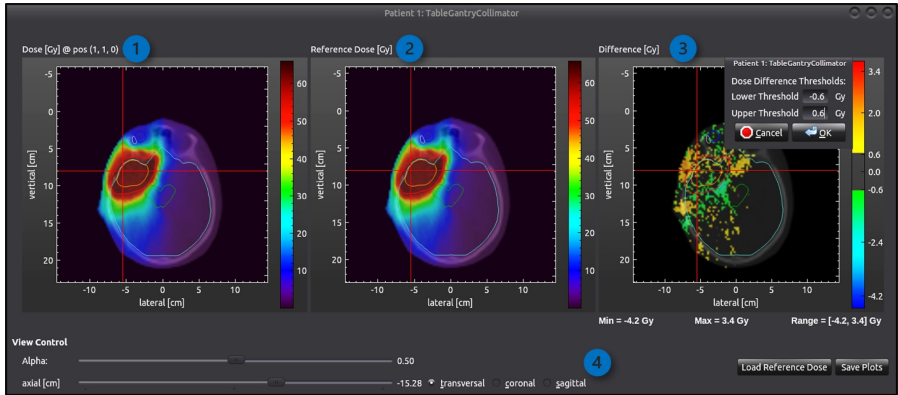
The dose window (opened by figure 2.3, number 6) displays dose distributions superimposed on the CT. Structures are indicated by the fine lines (PTV and CTV in red and orange here). 1: Dose of current scenario, 2: Reference dose, 3: Dose difference between reference and current dose, includes a user-defined threshold to visualize relevant dose ranges, 4: View control to switch through transversal, coronal, and sagittal plane. The red cross serves as a guideline when switching planes from transversal (shown here) to coronal or sagittal.
